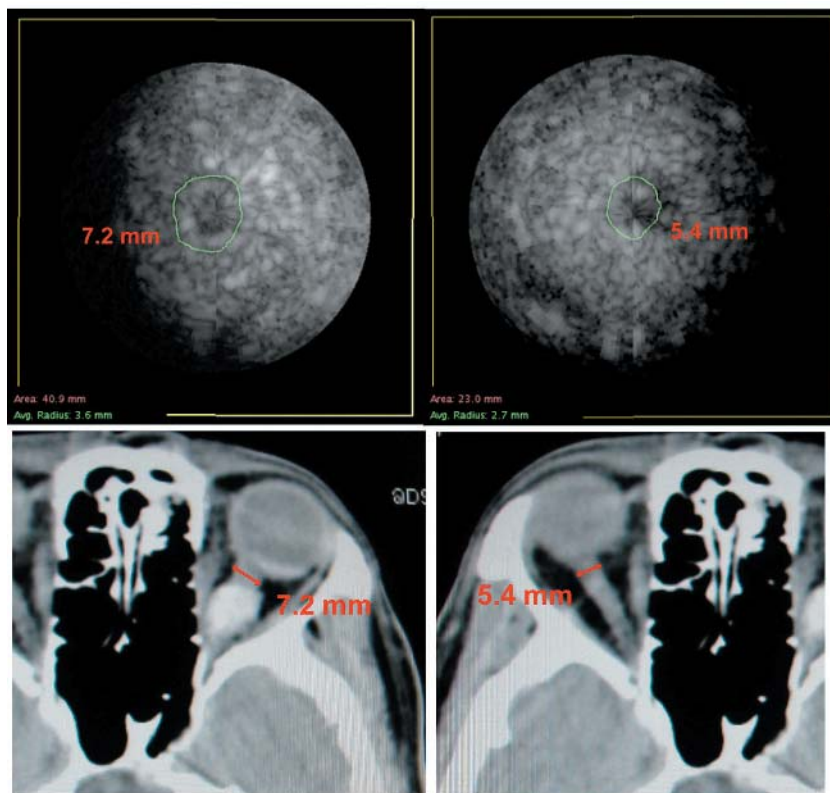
Case 2. The patient's left (top left) and right (top right) optic nerve sheath diameters are shown by 3DUS coronal C-scans. The patient's left (bottom left) and right (bottom right) optic nerve sheath diameters are shown by axial CT scans.
